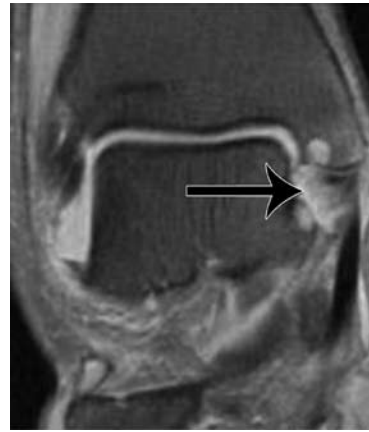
A MRI example of sprain.
